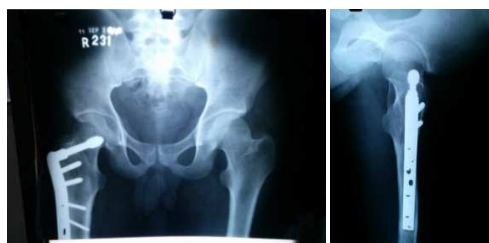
Follow-Up Radiographs
